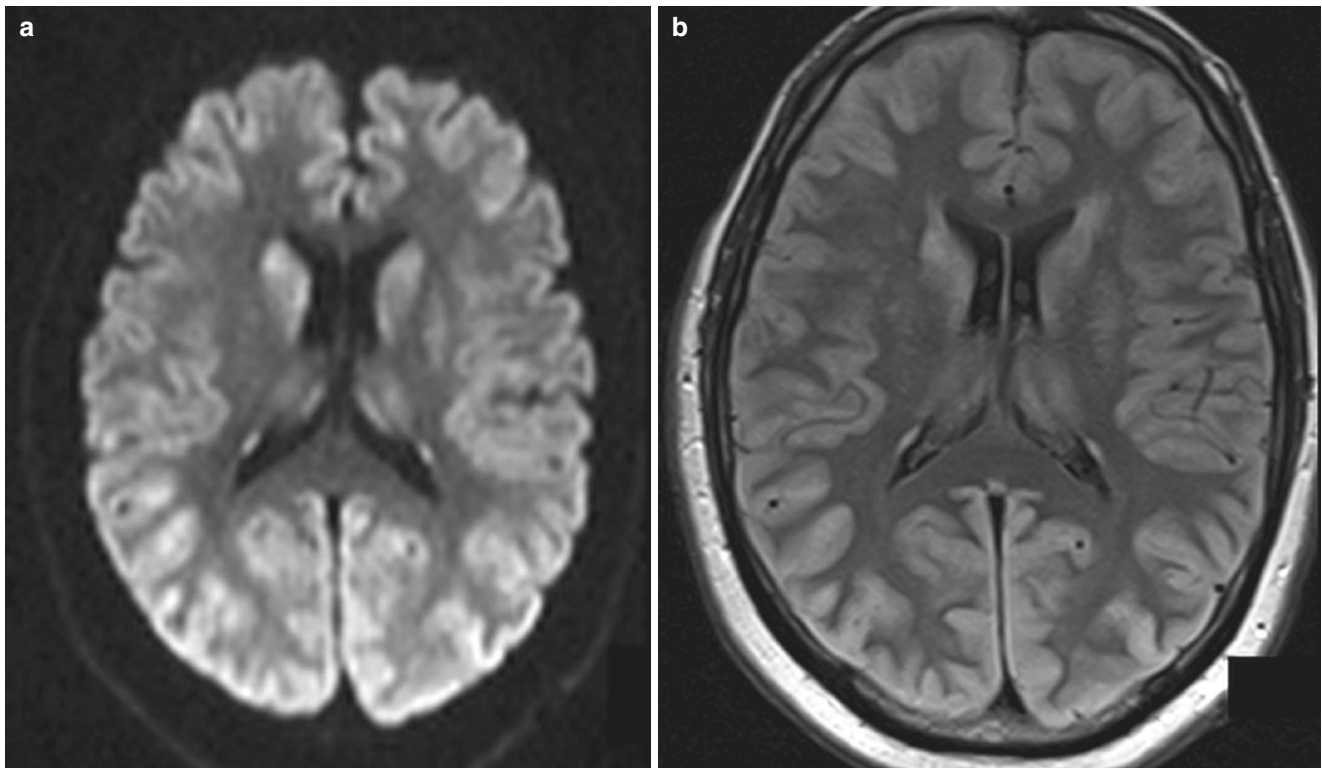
Hypoxic–ischemic encephalopathy. MRI shows diffusion restriction (a) and FLAIR hyperintensity and cortical swelling (b) of bilateral cerebral hemispheres and basal ganglia, consistent with cytotoxic injury
